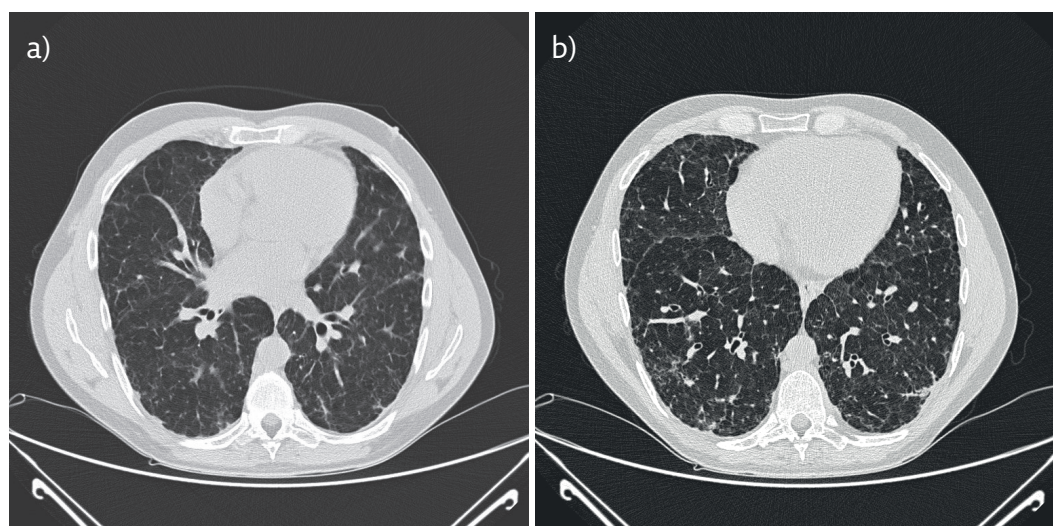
a) High-resolution computed tomography in inspiration during follow-up (interval: 9-years). b) Follow-up CT with disappearance of ground-glass opacities with progression towards a reticular interstitial pattern.
